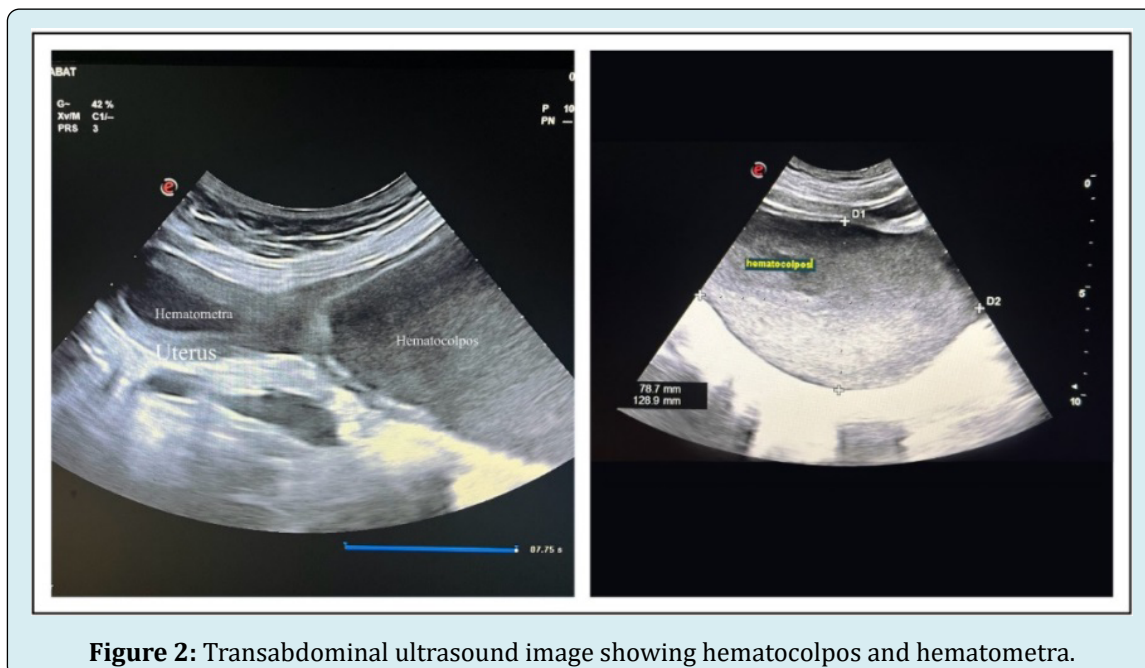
Transabdominal ultrasound image showing hematocolpos and hematometra.
